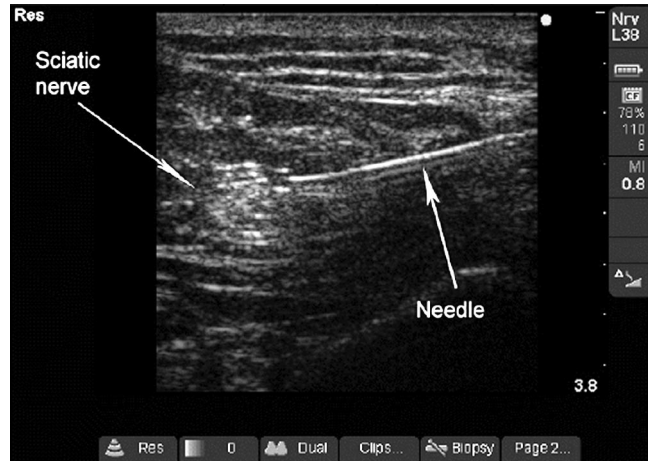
Posterior to anterior, short axis ultrasound image of the sciatic nerve using a 12 MHz L38 probe (MicroMaxx, Sonosite). The piezoelectric modified Tuohy needle (Contiplex, B. Braun) is approaching the sciatic nerve from lateral to medial.
